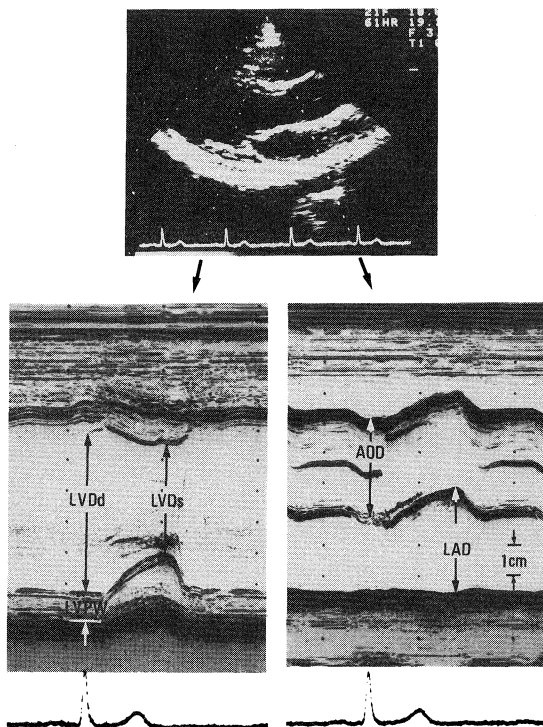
Methods for measuring diameter. Diameters were measured by standard procedures as shown, using two-dimensional and M-mode echocardiograms.
